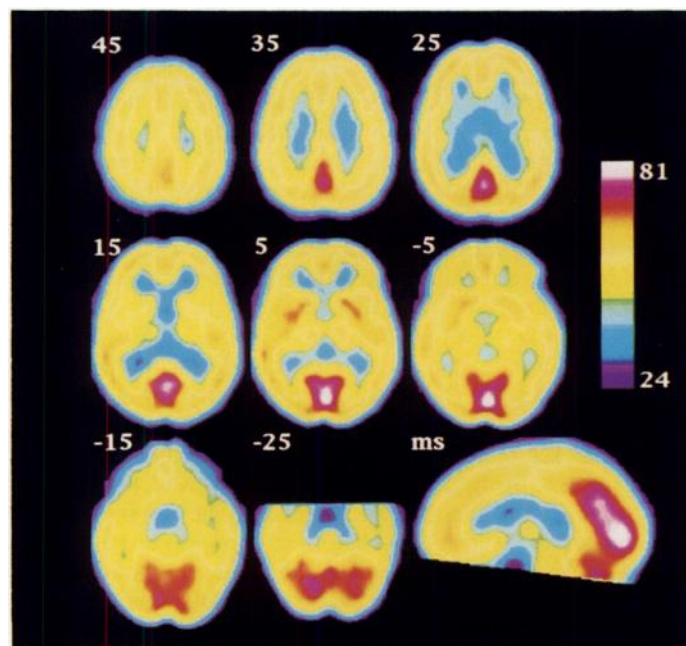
Mean images of anatomically standardized  $^{99m}\text{Tc}$ -HMPAO SPECT. All slices except the bottom right ones are parallel to the horizontal plane through the AC-PC line (top left: 45 mm above the AC-PC line and after pictures at 10-mm interslice intervals). The anterior is at the top of the image and the subject's right is at the left. The mid-sagittal section is shown at bottom right (ms). The anterior is at the left of the image. Images were thresholded at the upper and lower limits of 78 and 23 counts, respectively.
